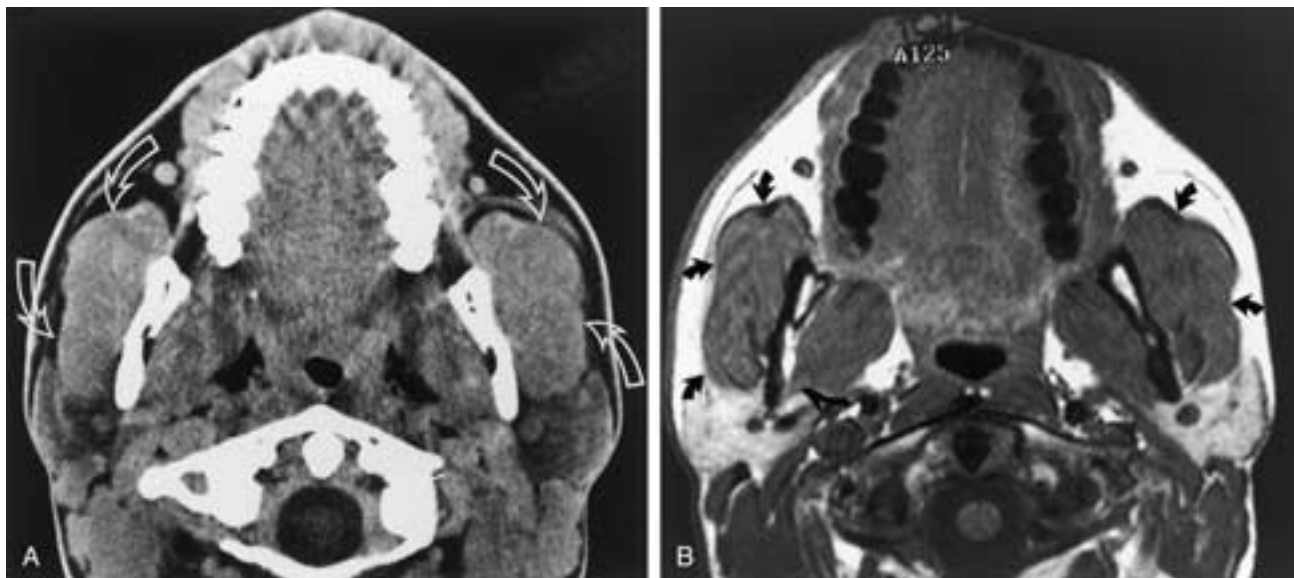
Benign masseteric hypertrophy. (A) Axial CT scan without contrast enhancement and (B) T1-weighted MR image reveal marked bilateral enlargement of the masseter muscles, which are otherwise normal in density/signal intensity and contour (arrows). (Courtesy of Dr. Deborah Reede.)
